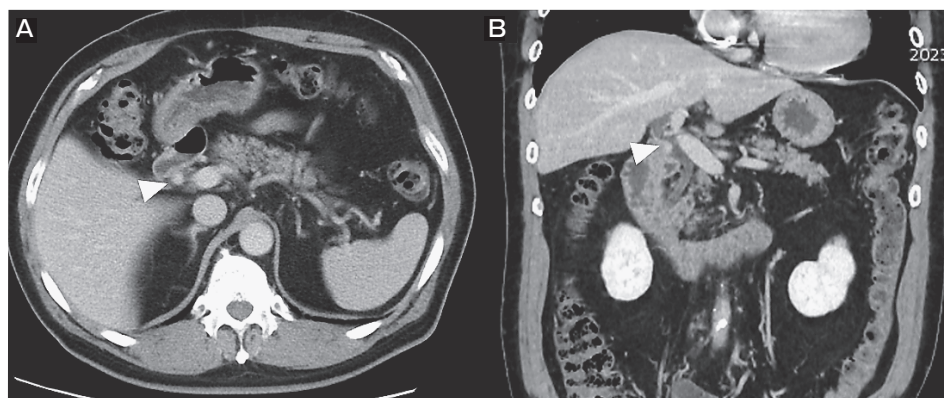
Contrast-enhanced computed tomography showed an enhanced nodule in the extrahepatic bile duct (arrowhead).
